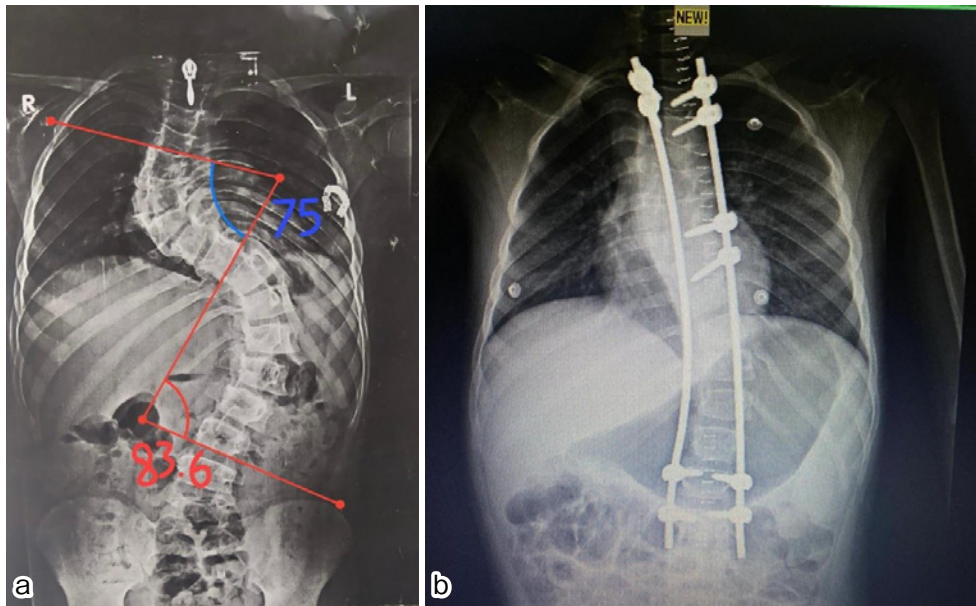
Figure 1 shows (a) preoperative and (b) postoperative X-rays using the double rod technique.
